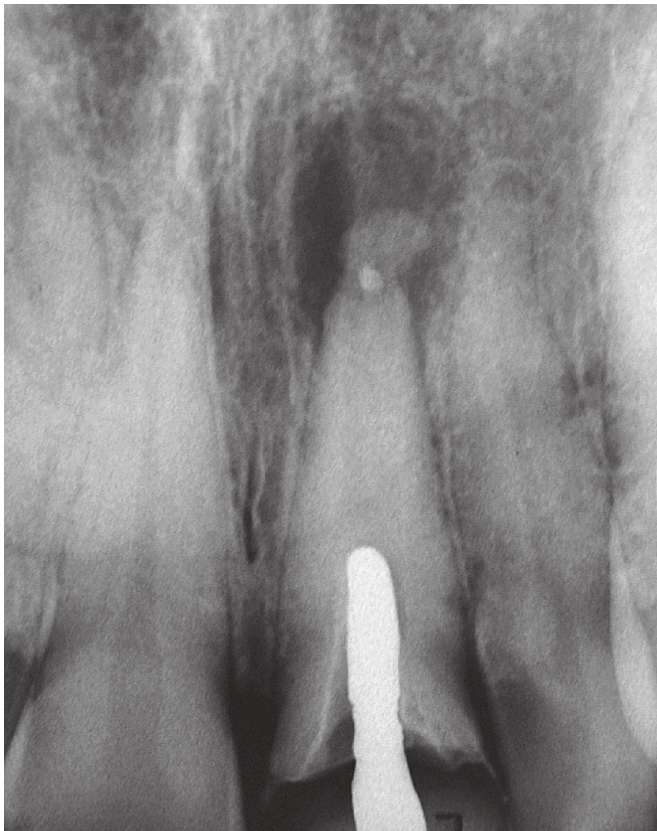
Periapical radiograph with intracanal dressing.
